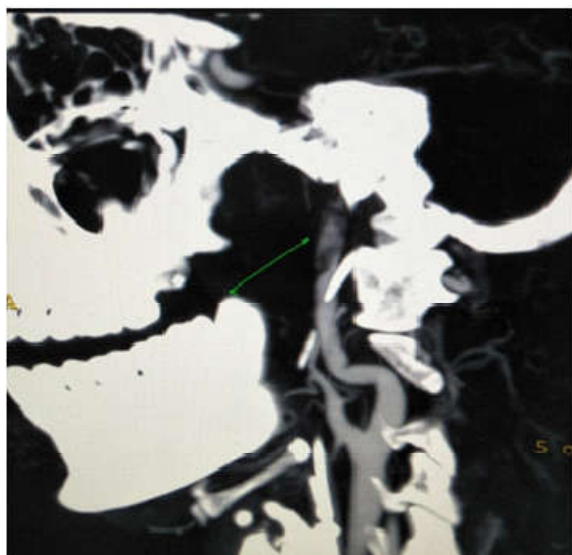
CT Angio Right side
